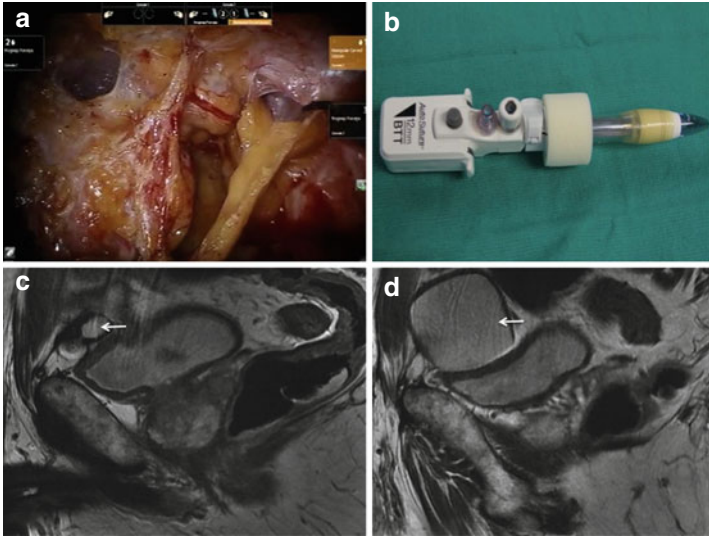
(a) Extensive intra-abdominal adhesions. (b) Balloon port device use to establish an air-tight seal after open entry. (c, d) Sagittal T2-weighted Pelvic MRI demonstrating full penile prosthesis reservoir (*arrow*) in close anatomic relation to the bladder
